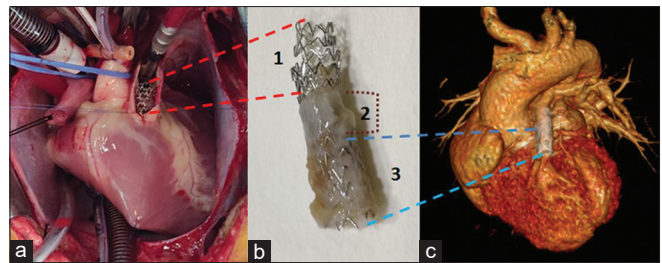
(a) Intraoperative findings after opening the main pulmonary artery longitudinally demonstrating the RVOT stent. (b) Explanted stent in toto with surrounding cardiac tissue. (c) CT scan with 3D reconstruction demonstrating the RVOT stent with adequately grown branch PAs. RVOT - Right ventricular outflow tract, CT - computerized tomogram, 3D - Three-dimensional
